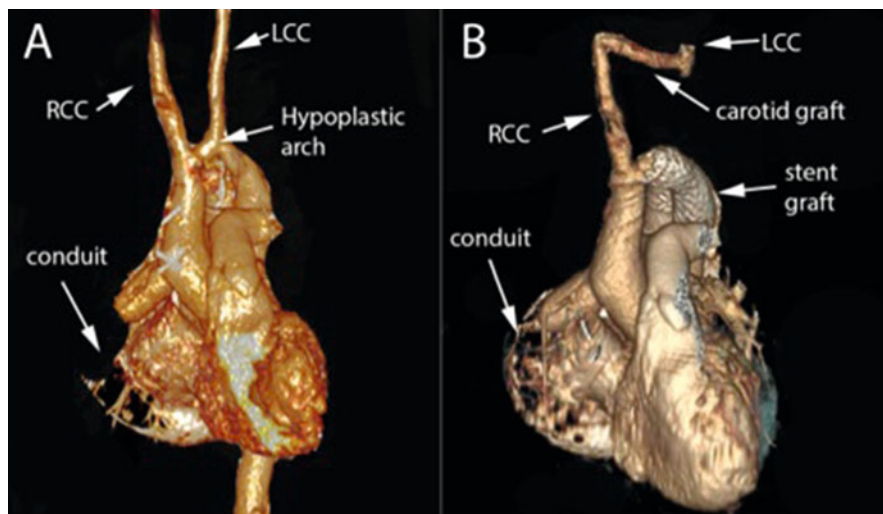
(a) CT angiogram with 3-D volume rendering, shallow left anterior oblique view, demonstrating a hypoplastic aortic arch in a patient that had previously undergone surgical placement of an ascending to descending aortic conduit. The conduit had subsequently thrombosed. The right common carotid (RCC) and left common carotid (LCC) are labeled. The left subclavian artery is not visualized because it had previously been utilized to surgically augment the aorta as a subclavian flap. (b) Covered aortic stent graft placement within the aortic arch has increased the arch diameter. A surgically placed carotid bypass graft ensures flow from the patent RCC to the LCC
